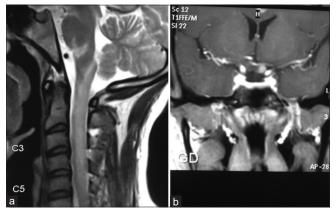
(a) MRI spine T2 weighted image showing lesion in cervical region extending up to medulla (b) MRI orbit contrast coronal cut showing left optic nerve posterior segment enhancement in AQP-4 antibody positive patient
